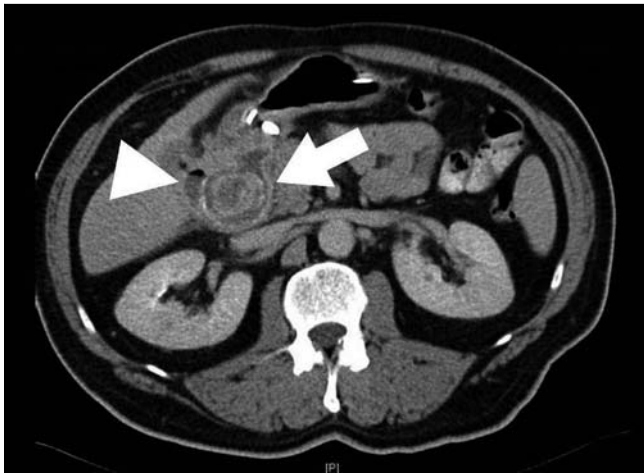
Computed tomography (CT) scan showing the gallstone that had penetrated into the duodenum (arrow) and an air crescent in the gallbladder (arrowhead).
